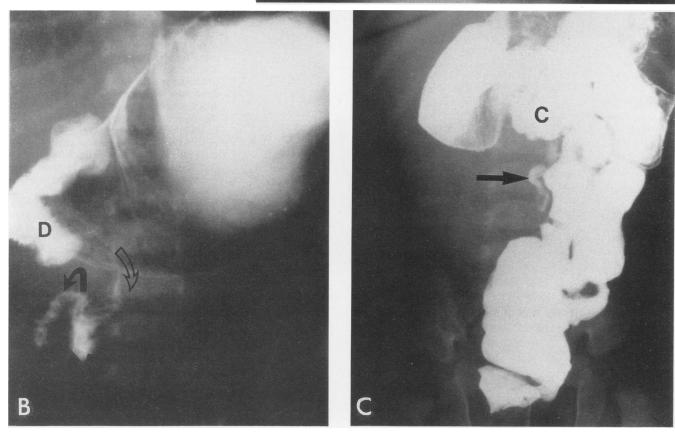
Fluoroscopic and spot-film identification of the cecum may be difficult on barium enema study. (A) Plain film of a child with bilious emesis showing a markedly dilated stomach and a paucity of distal small bowel gas. (B) The complementary barium enema study showing an apparently normal position of the large intestine. At celiotomy, the cecum was found placed abnormally high in the left upper quadrant. (C) Upper gastrointestinal study of the same patient, performed 12 hr after the barium enema study, showing a classic corkscrew appearance of the duodenum typical for midgut volvulus (arrow).
